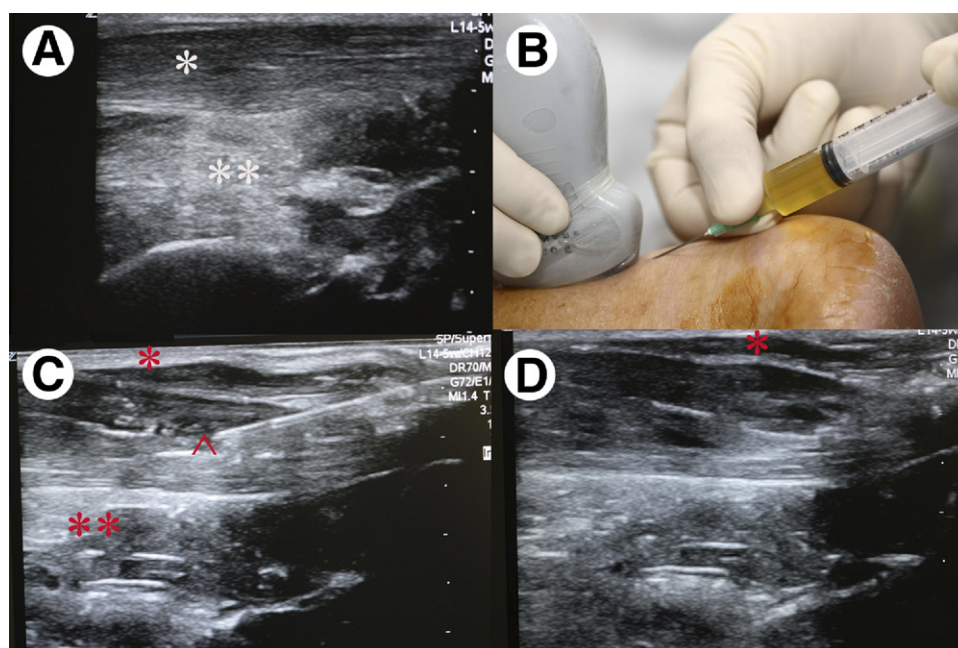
PRP injection for the treatment of Achilles tendinopathy. Ultrasound images show tendon, white asterisk; fat, double white asterisk; paratenon, red asterisk: (A) Ultrasound view of Achilles tendon (*) and associated fat () immediately before PRP injection; (B) The needle is inserted under ultrasound guidance from distal to proximal, in a parallel track to the collagen fascicles; (C) Intratendinous (*) injection of plasma, ^needle tip immediately adjacent to injected plasma; (D) Ultrasound image shows PRP injected between the tendon and paratenon (red asterisk) and plasma injected within the Achilles-associated fat. Plasma spreads when injected between the tendon and paratenon due to the laxity of the extracellular matrix. The goals are to inject the maximum volume that can be confined within the area of degeneration and to deliver some volume of PRP to the nearby tissue to activate tenocytes.
